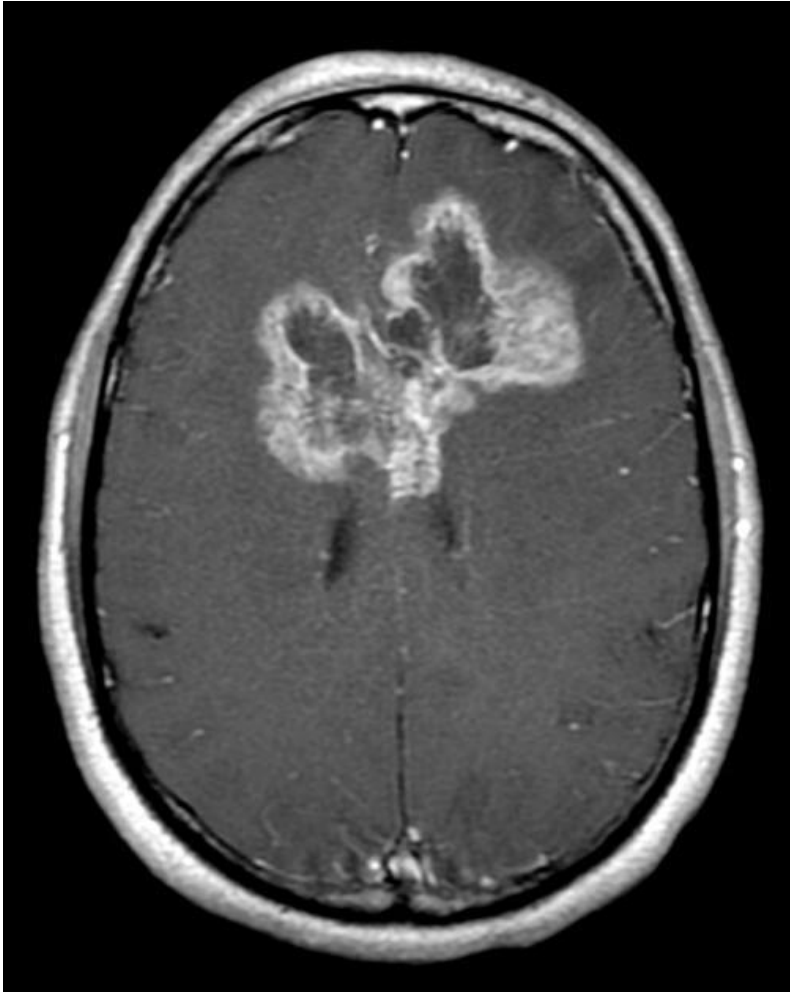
Magnetic resonance image from a glioblastoma tumor.
